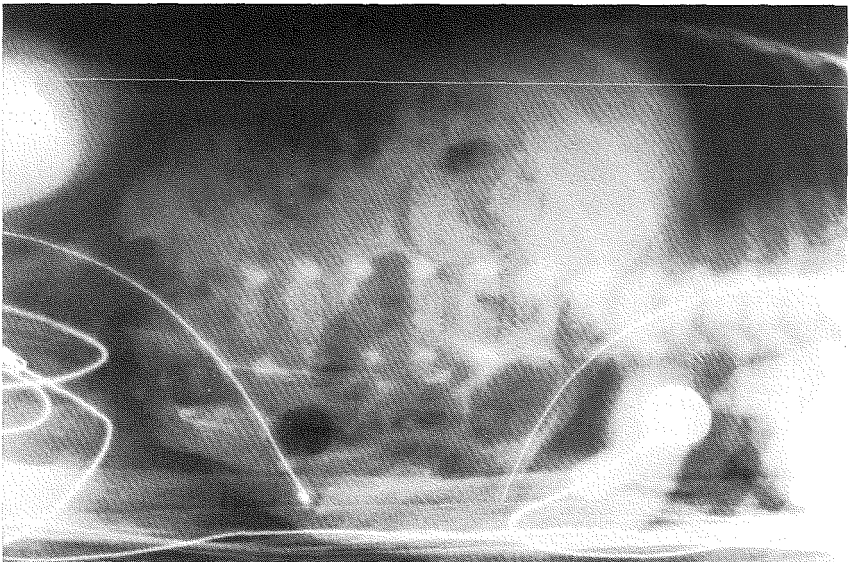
Abdominal radiograph of an infant with pneumatosis intestinalis and necrotizing enterocolitis.
